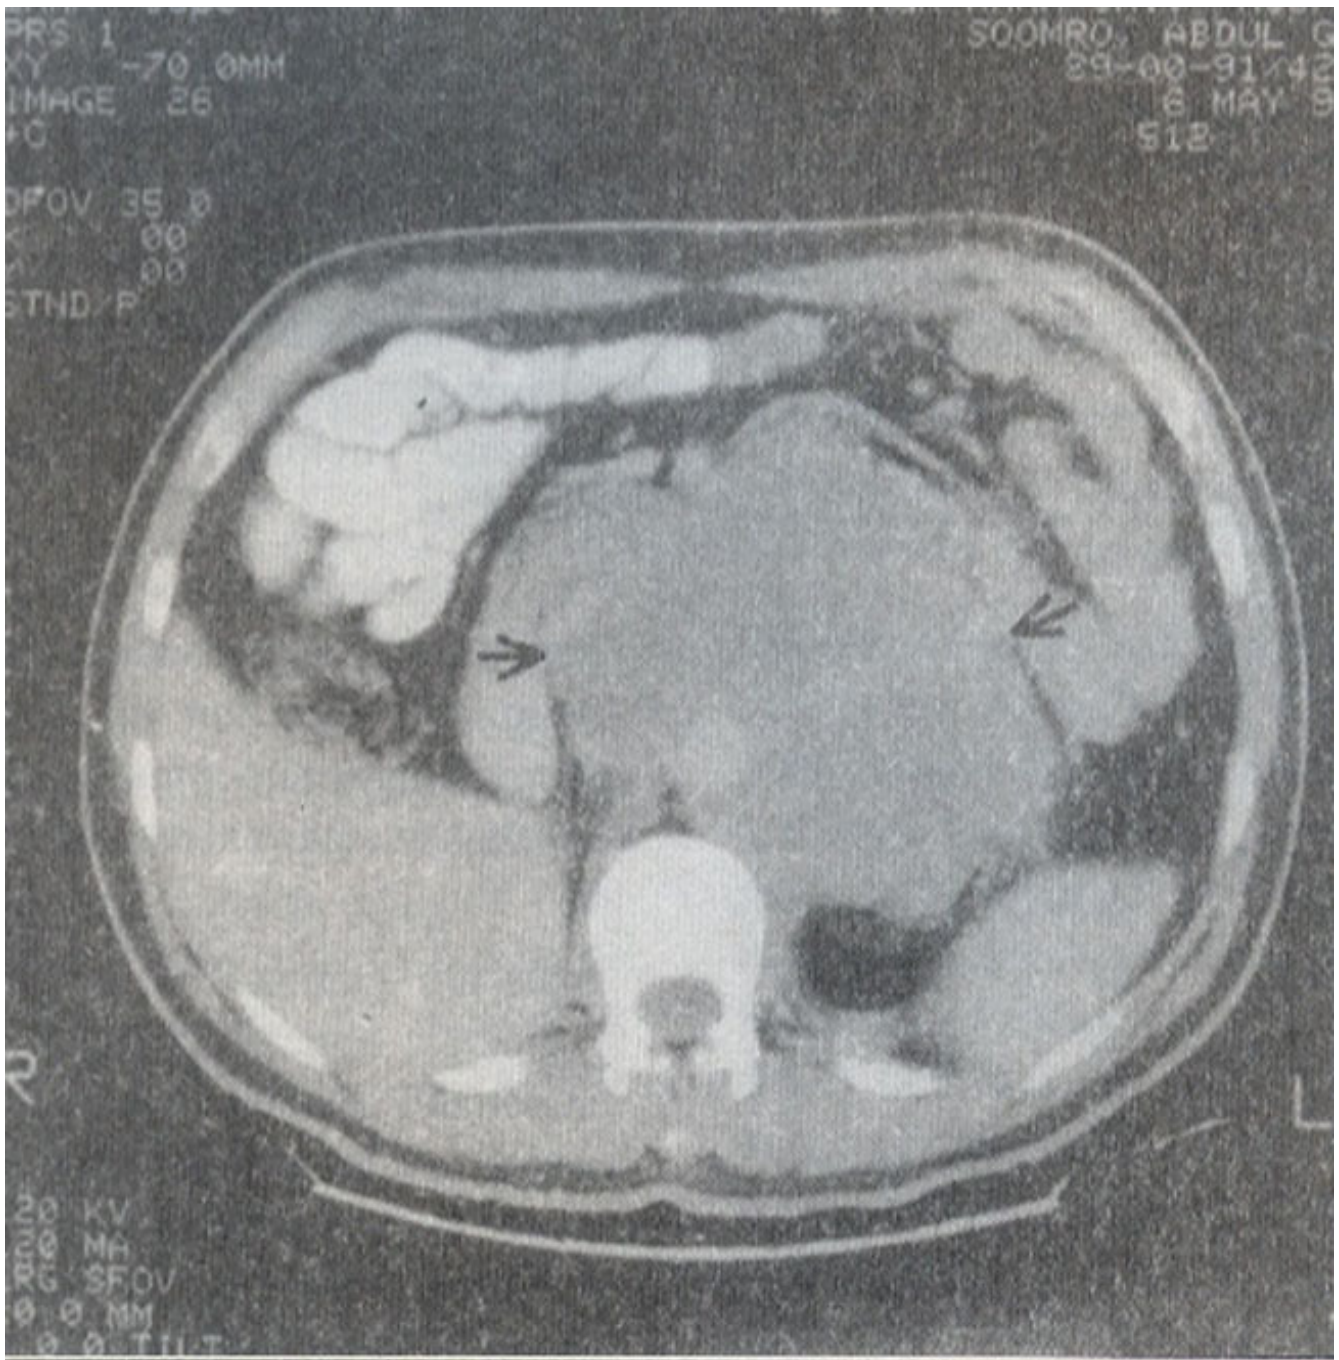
CT scan abdomen showing 20x18 cm para-aortic lymph nodal mass (arrows)
